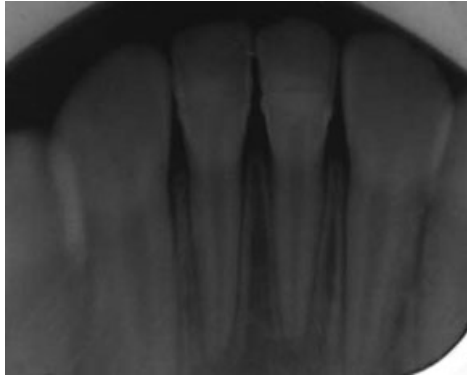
Dental X-ray film of the lower front teeth shows that the bilateral lower incisors and lateral incisors have no crown and root fractures and no expansion of the periodontal ligament space 1 month after trauma.
